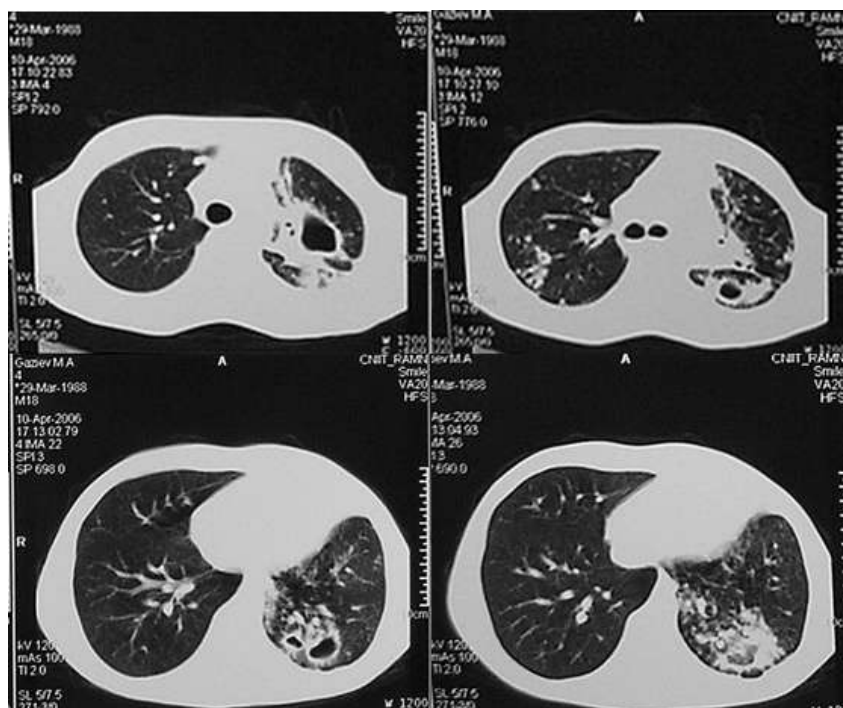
Computed tomography of patient G. Multiple caverns in the right lung with marked perifocal infiltration
